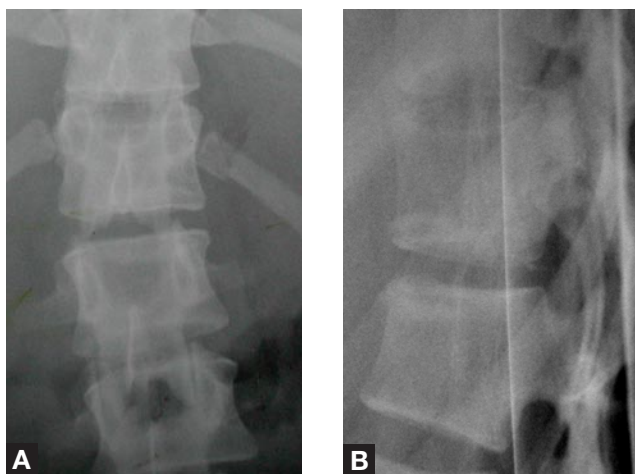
Anteroposterior (A) and lateral (B) preoperative x-rays of thoracolumbar junction. Note minor endplate changes and slight segmental deformity. The posterior interspinous process distance is widened, and the facet complex appears incompetent.
